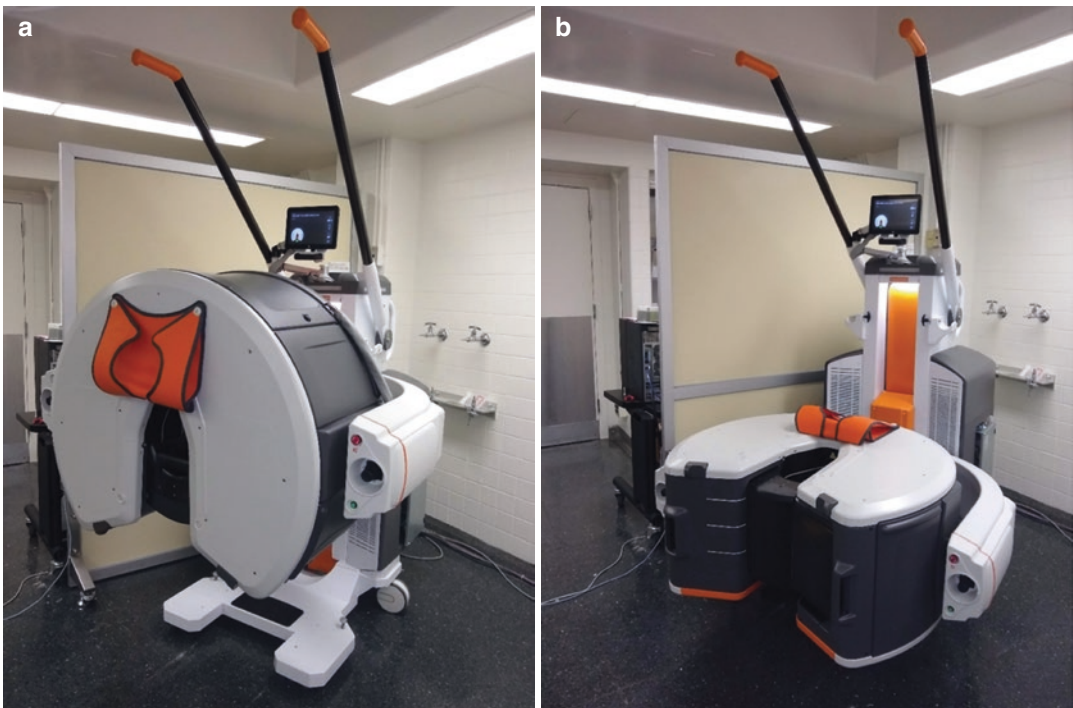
Extremity CBCT (Carestream OnSight3D) in a sitting configuration for imaging of non-weight-bearing upper and lower extremity (a) and in a standing configuration for weight-bearing scans (b)
